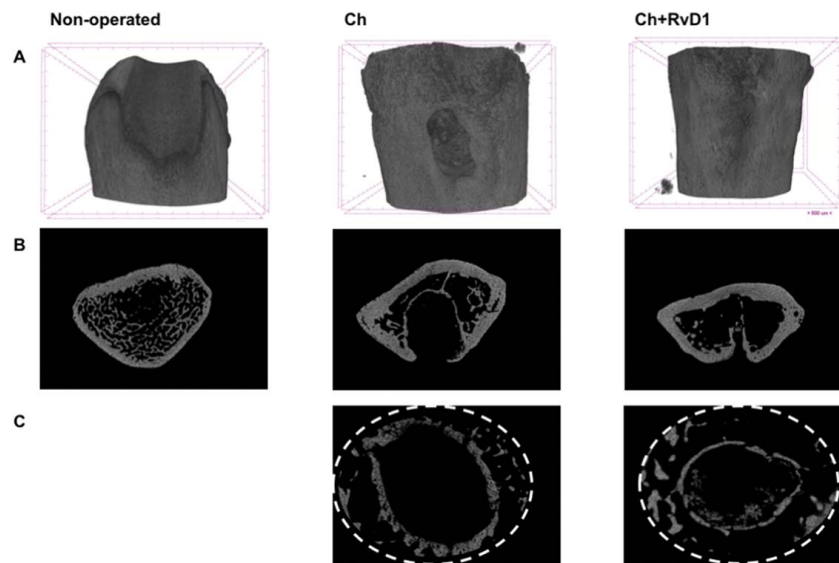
Micro-computed tomography (μ CT) images of bone defects. Samples were scanned with μ CT System (Skyscan, 1272). Images were reconstructed using NRecon software. (A) Reconstructed images of the defect area. (B) Transversal section of bone defects. (C) Representative images inside the defect.
